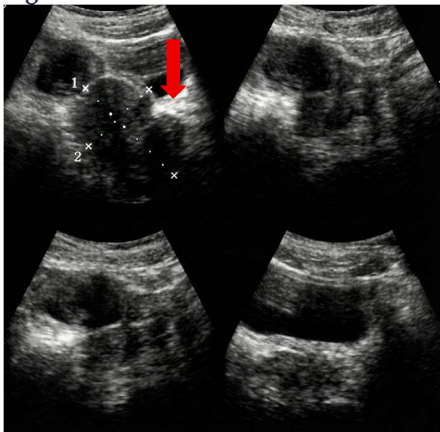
Pelvic ultrasound showing an empty uterus (red arrow).
